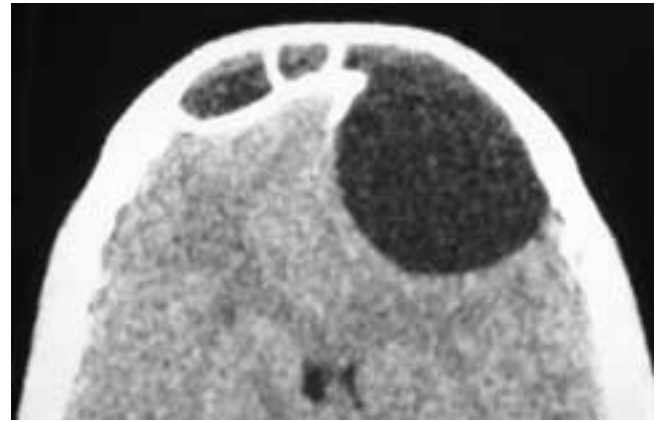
Axial CT scan shows a large, expansile mucoid attenuation mass in the left frontal sinus that has thinned the posterior sinus table and bulged intracranially. A smaller mucocoele that extended down into the orbit is also present on the right side. The left mucocoele contents are separated from the brain by sinus mucosa, deossified bone, and the meninges. This patient had bilateral frontal sinus mucocoeles.
